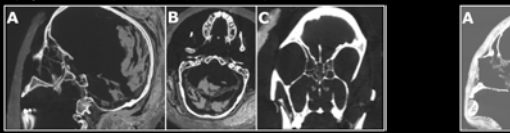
CT scan of ROM 910.5.3, showing (A) the intact brain, (B) the dural partitions, and (C) the intact turbinates, nasal septum, and ethmoid air cells.
